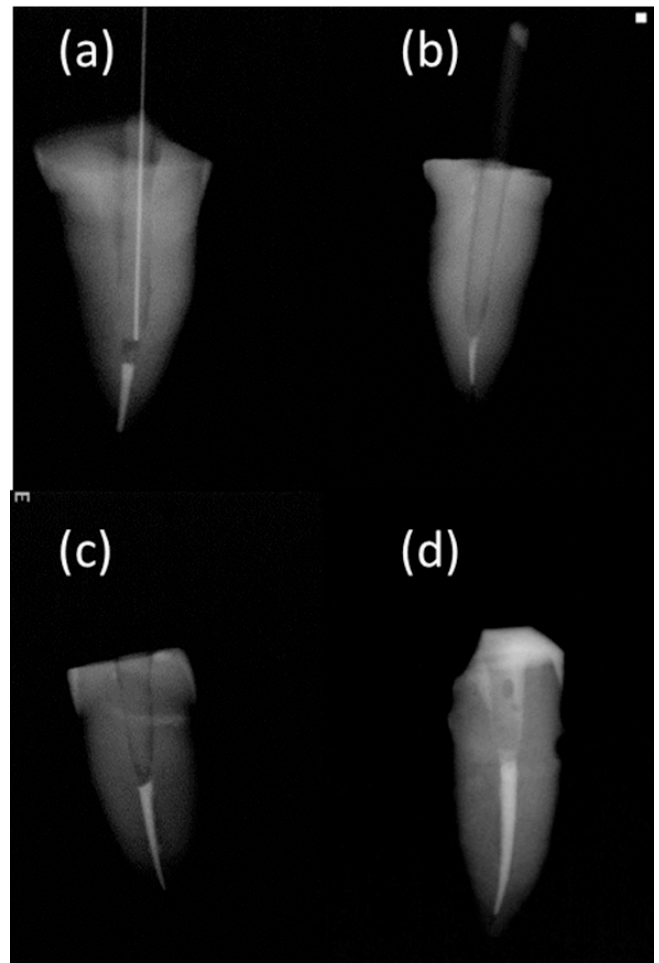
Radiographs confirming the posts fitting inside the prepared root canals, A: fiber posts $2/3$ length, B: dentin post $2/3$ length, C: dentin post $1/2$ length, D: dentin post $1/3$ length of the root canals.
